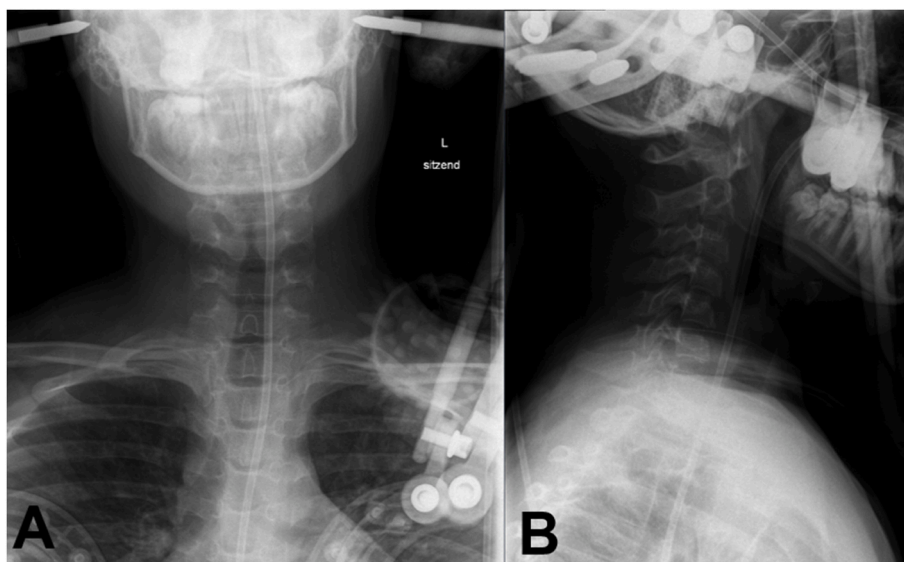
Sitting lateral and ap radiographs following halo fixation.
